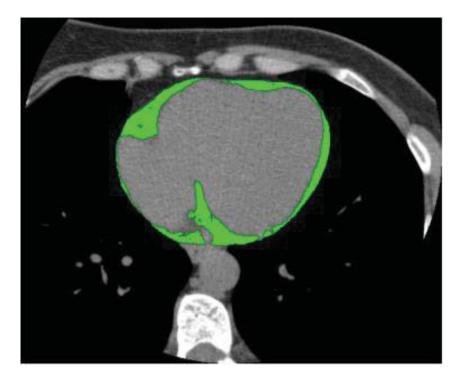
Epicardial fat measured by semi-automated method via cardiac CT
